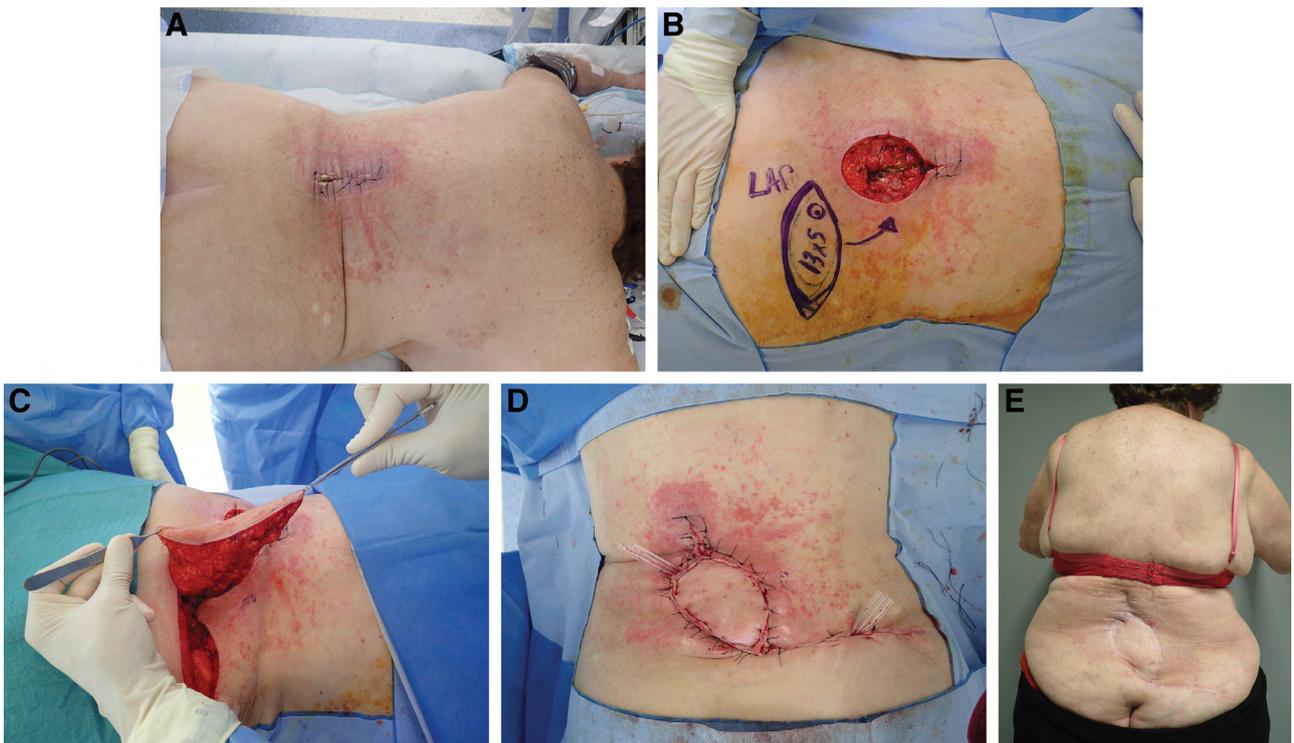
A, A 73-year-old patient having undergone osteosynthesis surgery for vertebral collapse presented with spondylodiscitis secondary to postsurgical wound dehiscence. B, Acoustic Doppler detection of chosen lumbar perforating arteries was performed. Debridement of the septic zone followed, collecting bacteriological samples. C, Flap rotation of approximately 100 degrees. D, Placement of flap and suture without tension on drainage. The donor site was primarily closed. E, Results at 6 months showing definitive healing.
